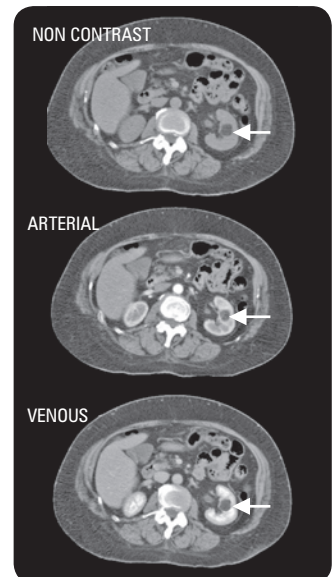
Triphasic CT of an angiomyolipoma: showing fat density with non-contrast scan, mildly enhancing with contrast
